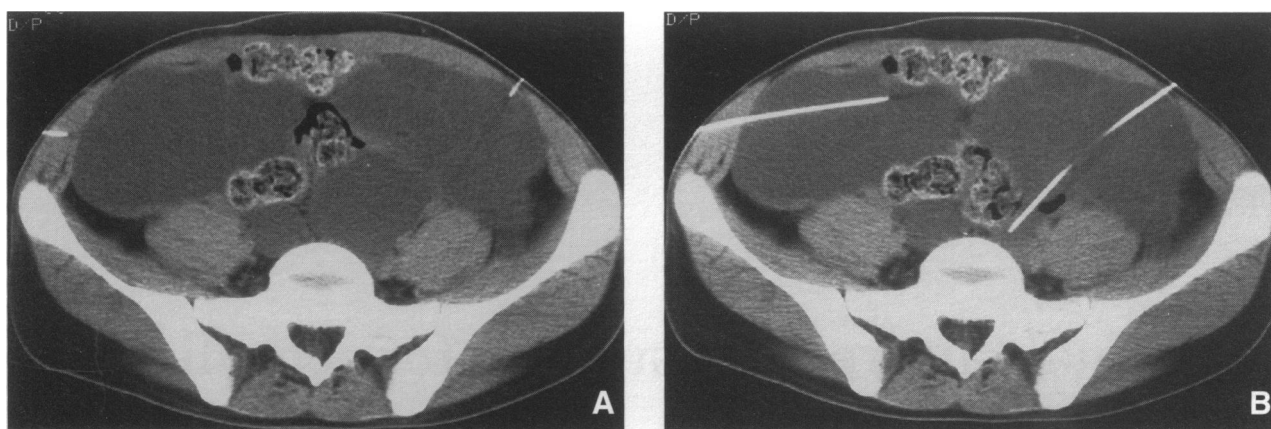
CT scans demonstrating (A) large cysts and (B) needle positions following aspiration of the left posteriorly placed cyst
